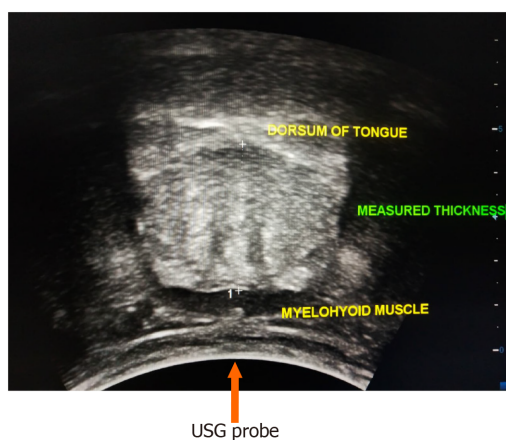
Vertical distance measured from the surface of the mylohyoid muscle to the tongue dorsum. USG: Ultrasonography.
